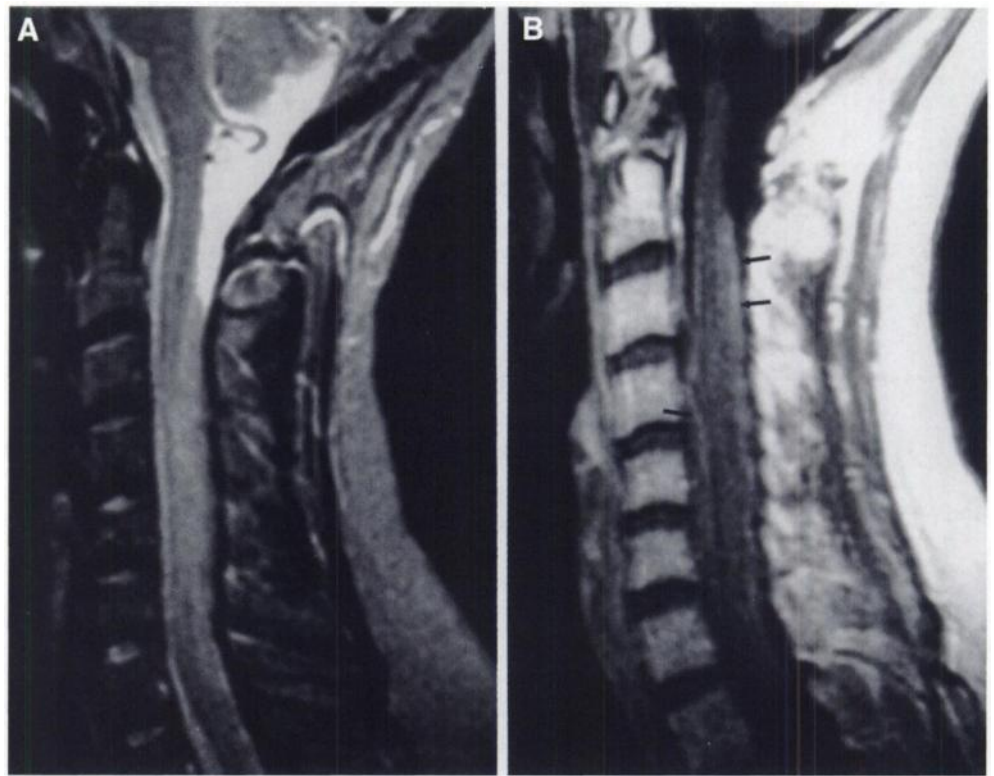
MRI of cervical spine. T2-weighted (echo time = 80; repetition time = 2000) (A) and T1-weighted (echo time = 15; repetition time = 400) after intravenous administration of gadolinium-DTPA (0.1 mmol/kg). (B) Sagittal MR images demonstrate long segment of fusiform dilatation of spinal cord with increased T2 signal and peripheral enhancement (arrow).
